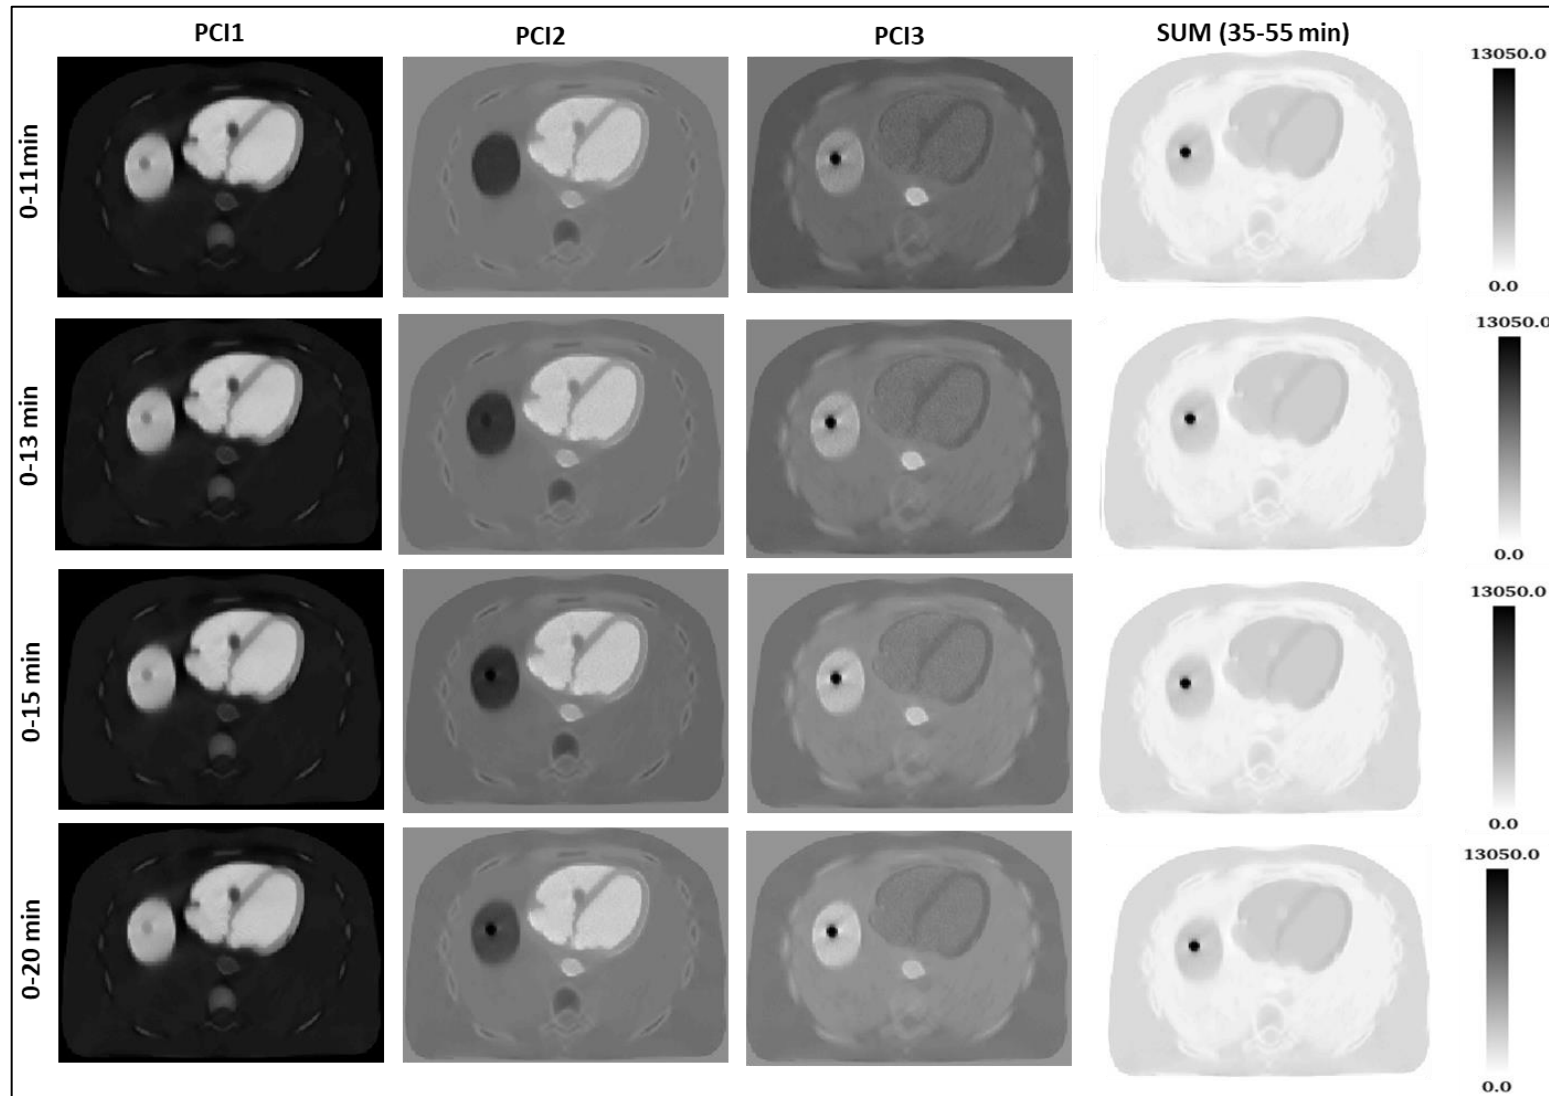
a Transverse slices obtained by the PCA method at 0-11, 0-13, 0-15 and 0-20 time intervals showing ^{18}F -FDG uptake in lesions and other tissues. The SUM images were generated at 35-55 min intervals as described above.
